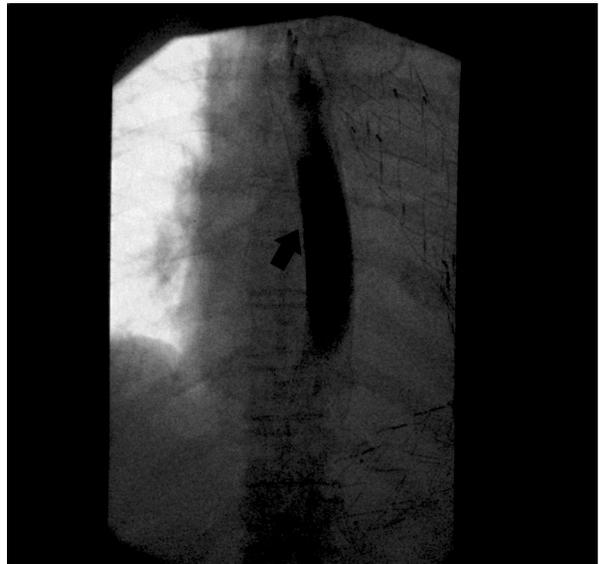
Case report 1. Esophagus x-ray examination showing the tightness of the SEMS prosthesis (black arrow)
